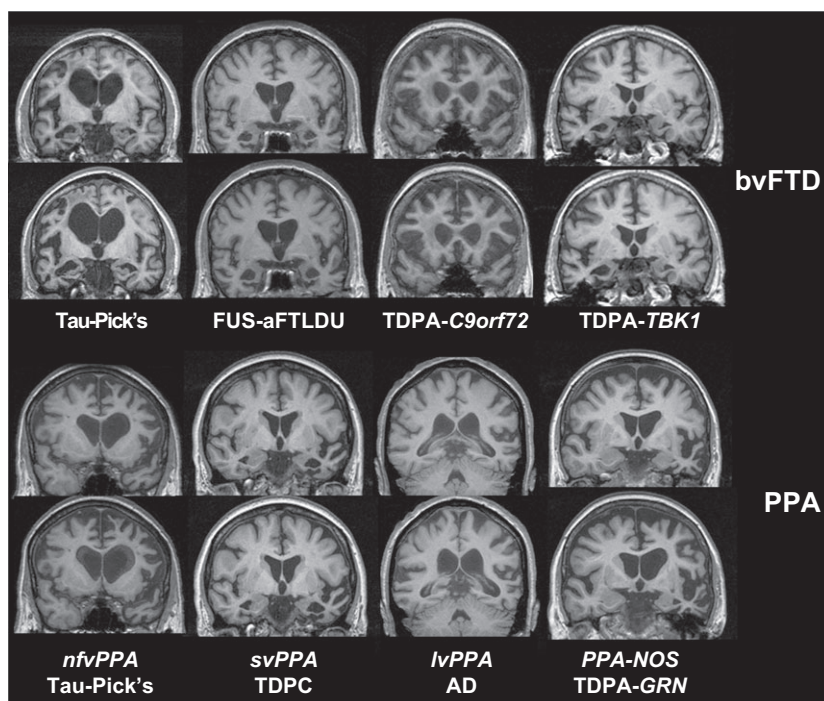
MR imaging features of different forms of frontotemporal dementia with both baseline coronal T1 scan and longitudinal scan at approximately 1 year interval. Top row shows different pathologically confirmed cases of bvFTD with features of (i) variable frontal, temporal, insula and anterior cingulate involvement, (ii) variable asymmetry and (iii) variable rate of progression. Bottom row shows characteristic features of different PPA variants in pathologically confirmed cases: left frontal and insula involvement in nvPPA, focal left more than right anteroinferior temporal involvement in svPPA, left temporo-parietal atrophy in lvPPA and very asymmetrical frontotemporal atrophy in PPA-NOS due to a progranulin mutation.
